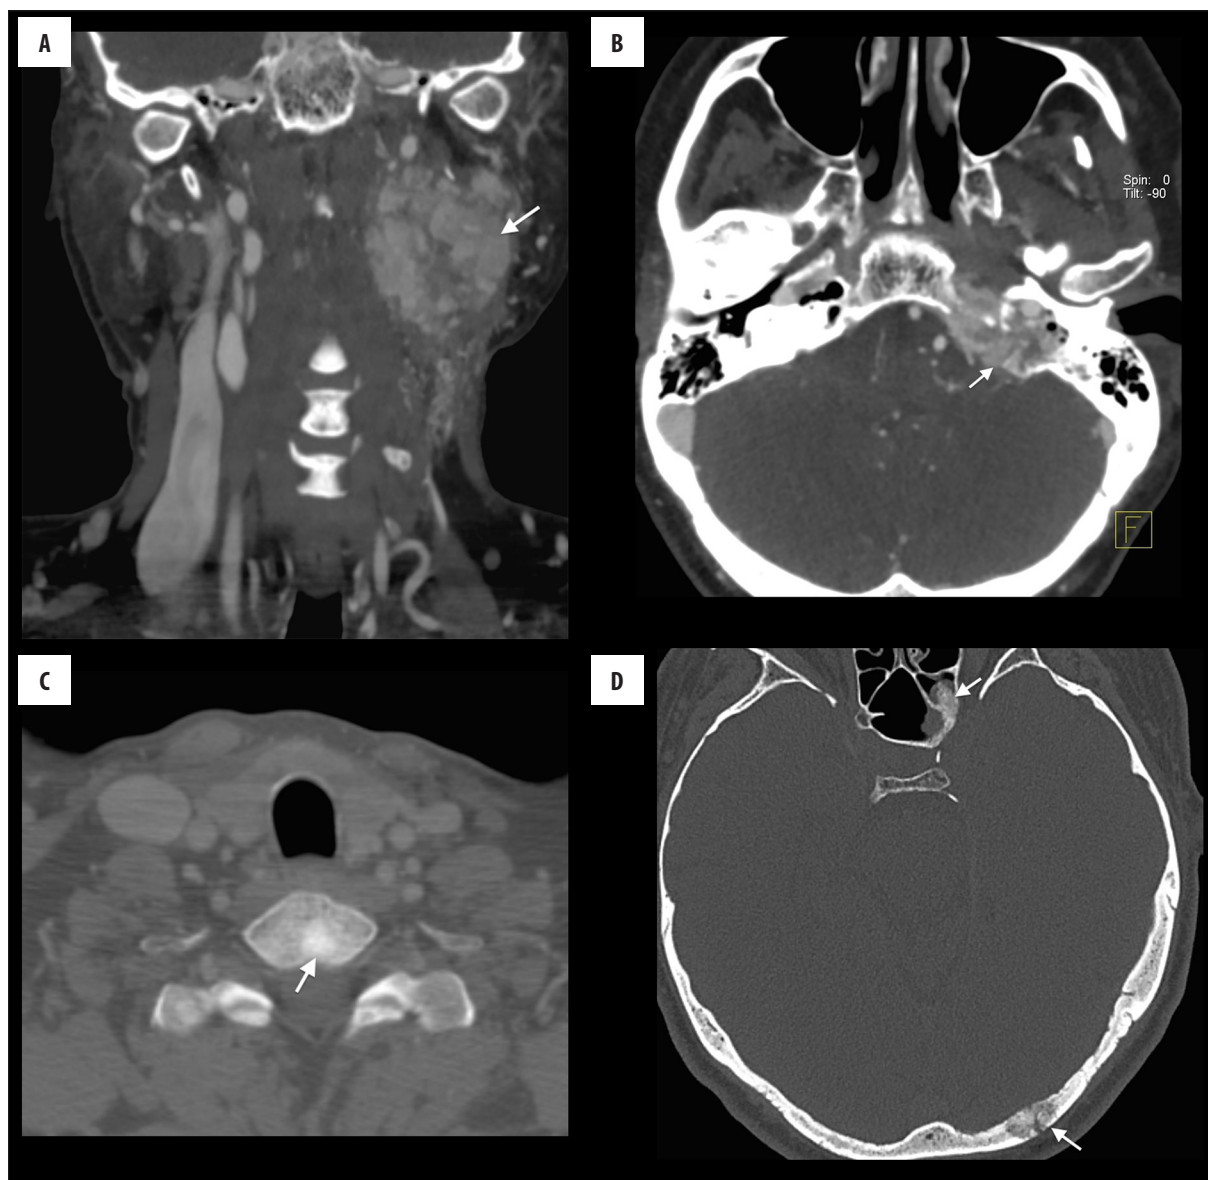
A 37-year-old man with malignancy *SDHB* mutation. (A, B) Contrast-enhanced CT, a-coronal, b-axial view, showing well-enhanced tumor mass extending from the carotid bifurcation to the left tympanum (arrows). (C, D) CT, axial views show osteoblastic metastases to the thoracic vertebrae and to the left occipital and sphenoid bones (arrows).
